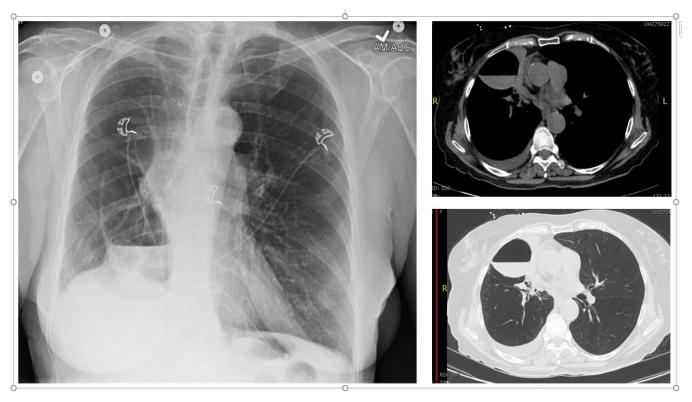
Chest X-ray and CT scan of the chest demonstrating the bullae with an air-fluid level in right upper lobe.
